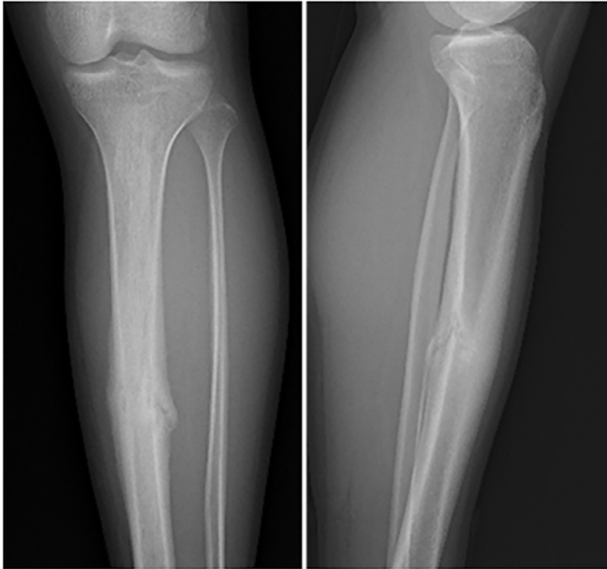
X-ray of the left tibiofibular.
